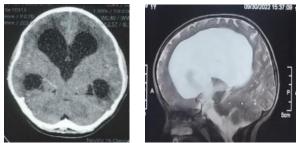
obstructive hydrocephalus with absent density in 4th ventricle. MRI image on T2 weighted image showed a congenital lesion of aqueductal stenosis
